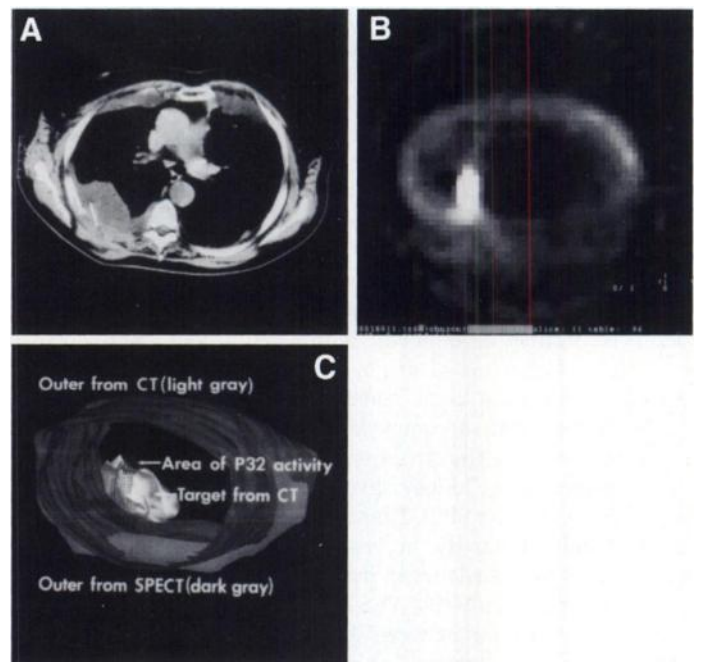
(A) Transverse CT image of a patient with lung disease shows the area of abnormality and the position of the needle. (B) SPECT transverse image of the same patient after ^{32}P injection shows the area of high activity. (C) Three-dimensional co-registration between CT (light gray) and SPECT (dark gray) outer surfaces. The target from the CT slices (solid) also is shown co-registered with the ^{32}P area of high activity (lines) from SPECT data.
